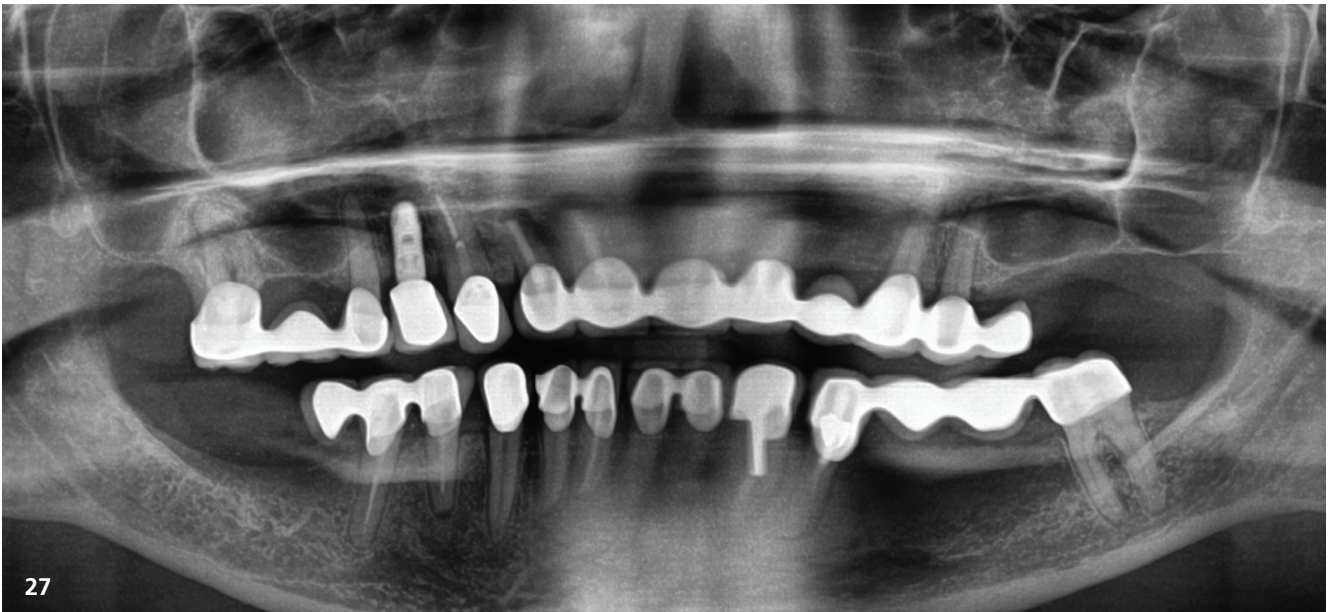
Final radiograph with the final restoration in place.
